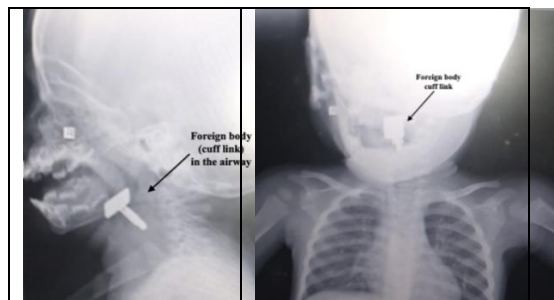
X-ray soft tissue neck showing FB (cuff link) in the laryngotracheal lumen. The flat cap of the cuff-link hangs in the supraglottic region while the stem passes in between the vocal cords to lie transglottic (a)-Lateral view (b) anteroposterior view
